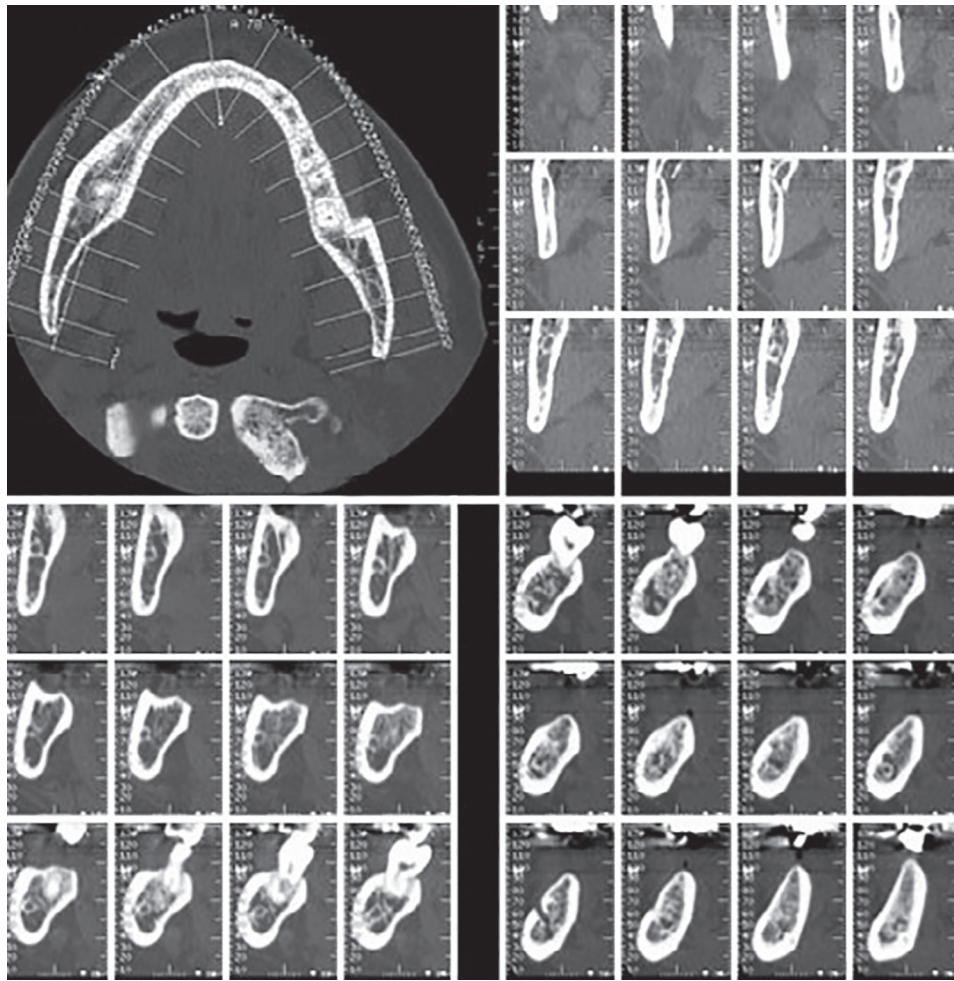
The CT-guided implant
